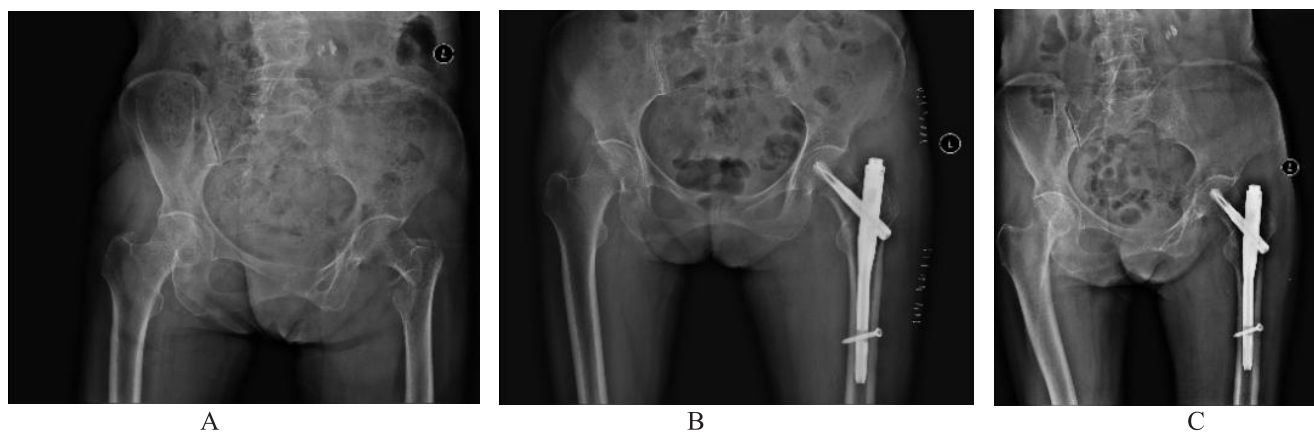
A shows the preoperative X-ray of the patient, B shows the postoperative X-ray, and C shows the follow-up X-ray 3 months after surgery
